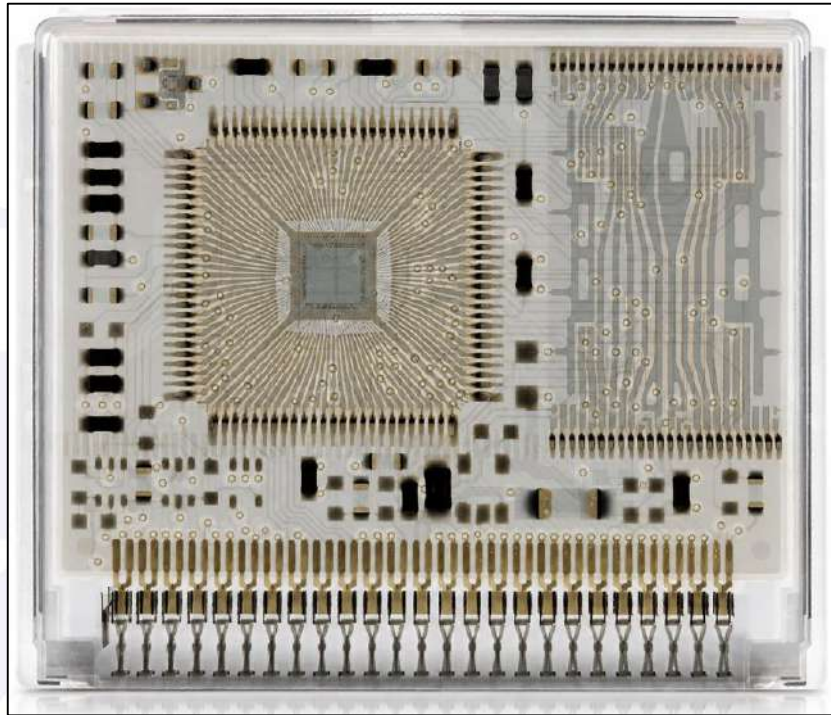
X-ray view of the PCMCIA flash memory.
